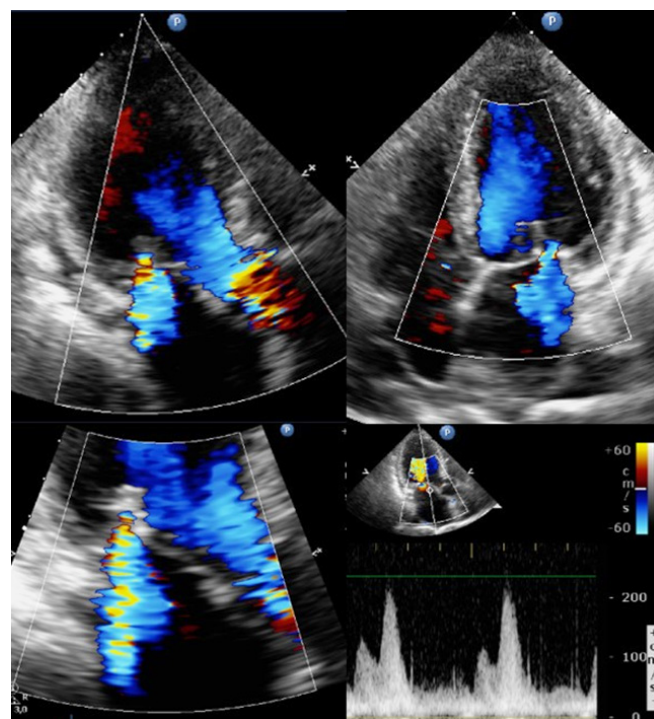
Discharge trans-thoracic echocardiogram showing residual mild mitral regurgitation and mean gradient of 5 mmHg
